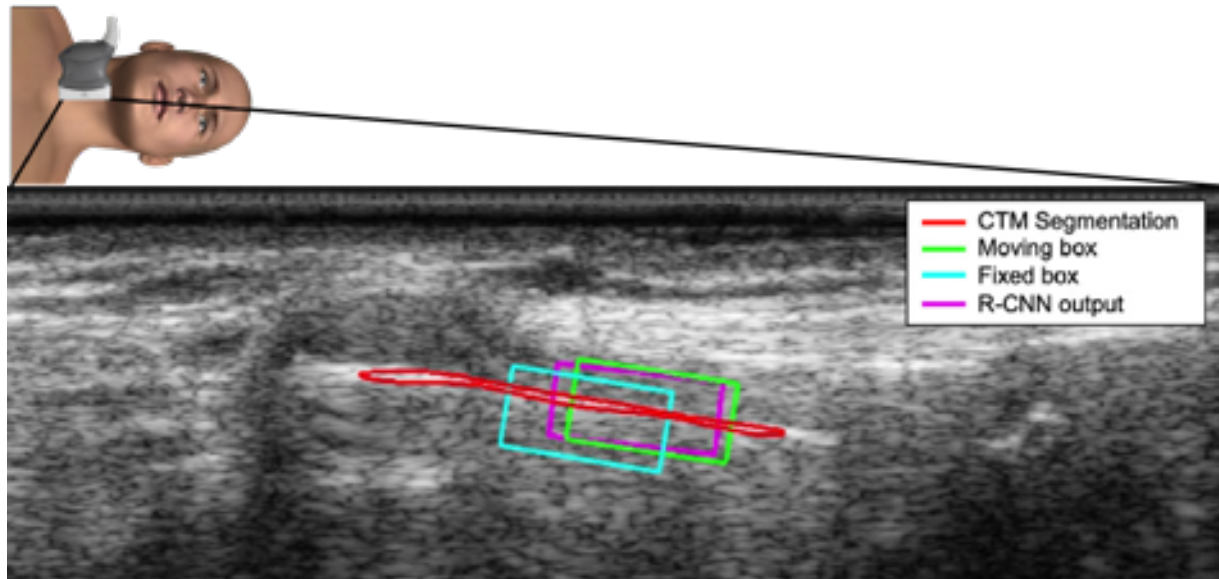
Example of ultrasound probe placement and resulting B-mode image frame, with corresponding CTM segmentation and boxes. Note that Doppler data is only collected from only a single ultrasound transducer element, though large boxes were used to ensure a large enough field of view for the R-CNN.
